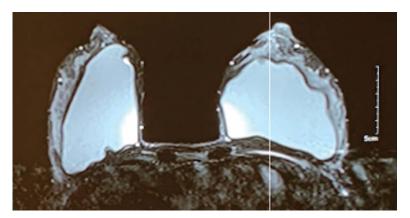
Preoperative breast magnetic resonance imaging. Notice irregular parenchyma distribution, with areas of significant thinning in the superomedial quadrants.
